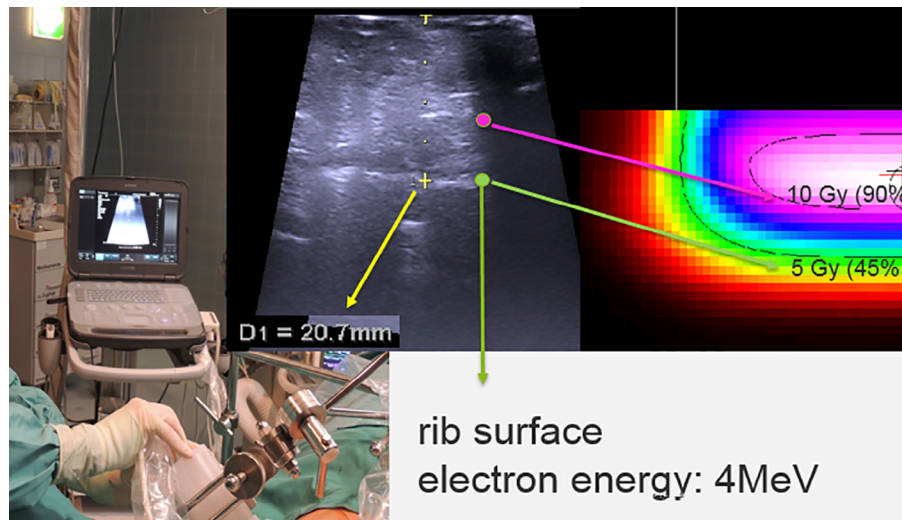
Tissue depth measurement by ultrasound (along the clinical axis), corresponding electron energy and dose prescription of D_{max} 11 Gy.
